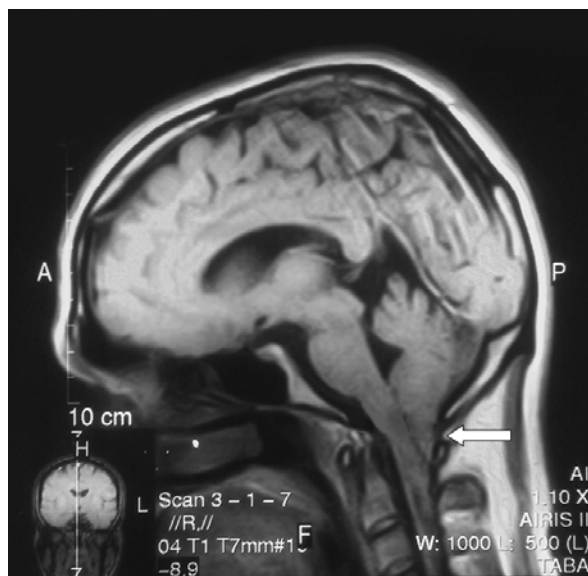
The brain MRI of the patient with SDB and Chiari type I malformation. The white arrow shows herniation of cerebellar tonsils through foramen magnum.
